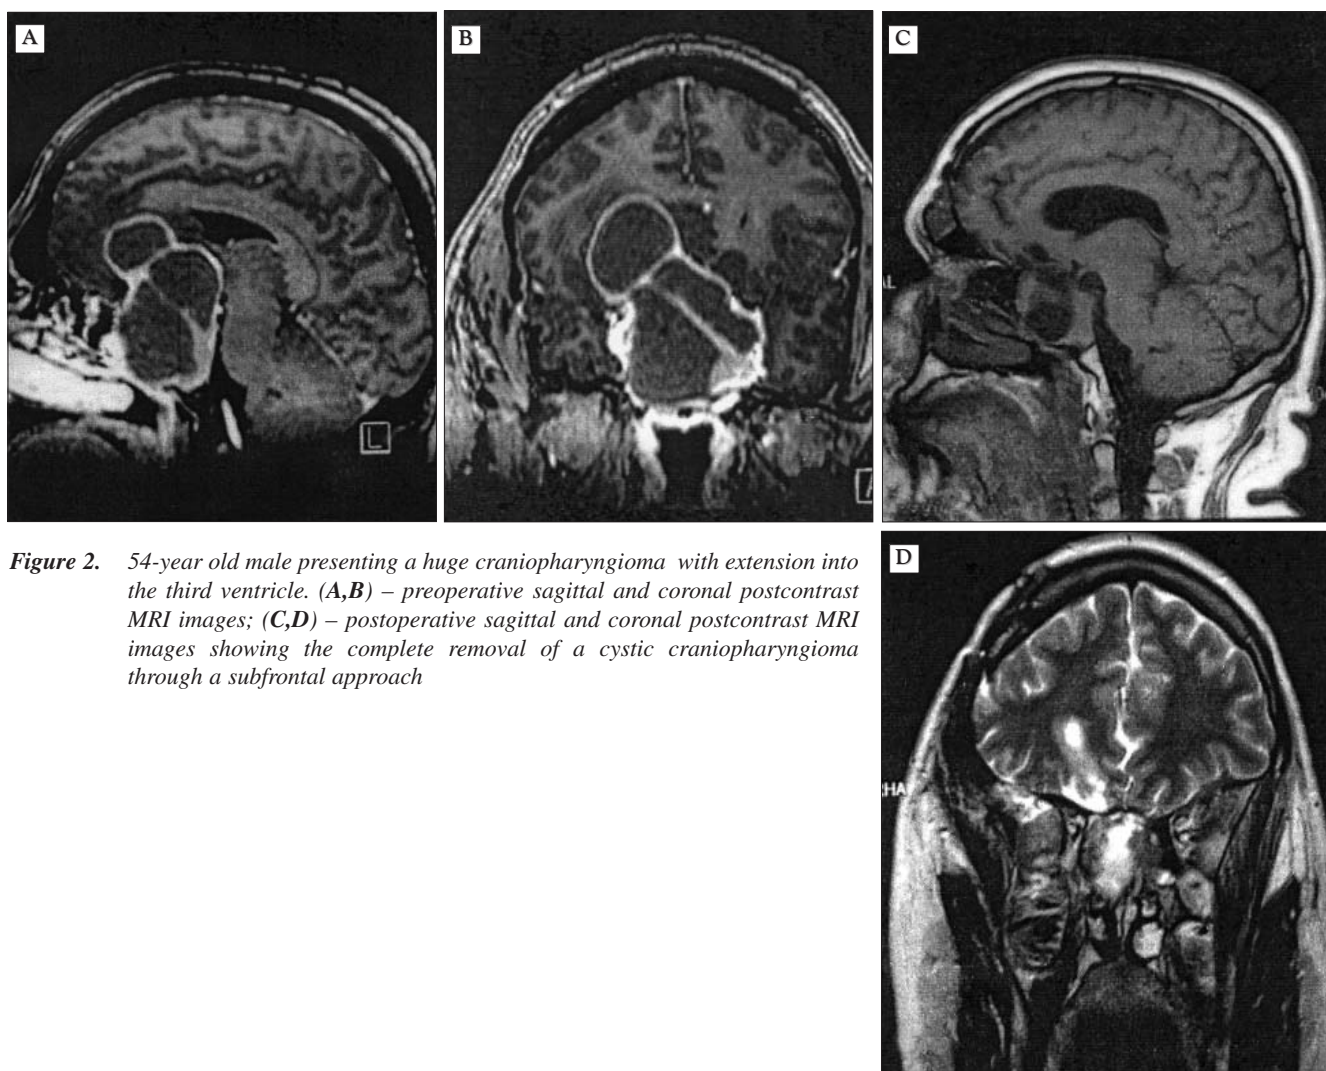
54-year old male presenting a huge craniopharyngioma with extension into the third ventricle. (A,B) – preoperative sagittal and coronal postcontrast MRI images; (C,D) – postoperative sagittal and coronal postcontrast MRI images showing the complete removal of a cystic craniopharyngioma through a subfrontal approach
